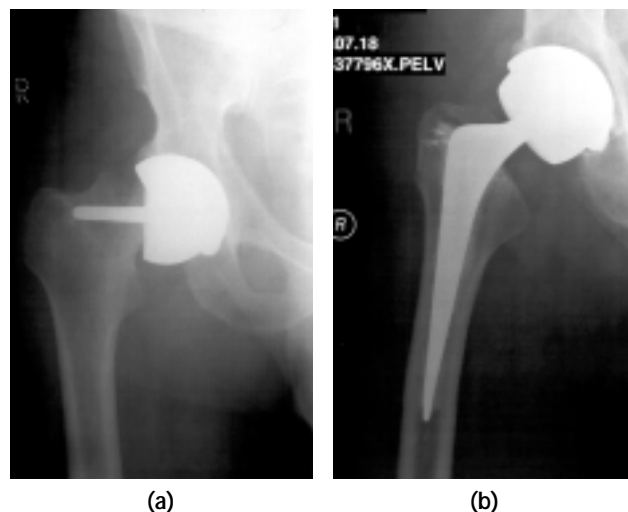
Case 2: (a) preoperative radiograph showing femoral neck fracture of the right hip with metal-on-metal hip resurfacing prosthesis *in situ*; (b) postoperative radiograph showing revision of the femoral component.
